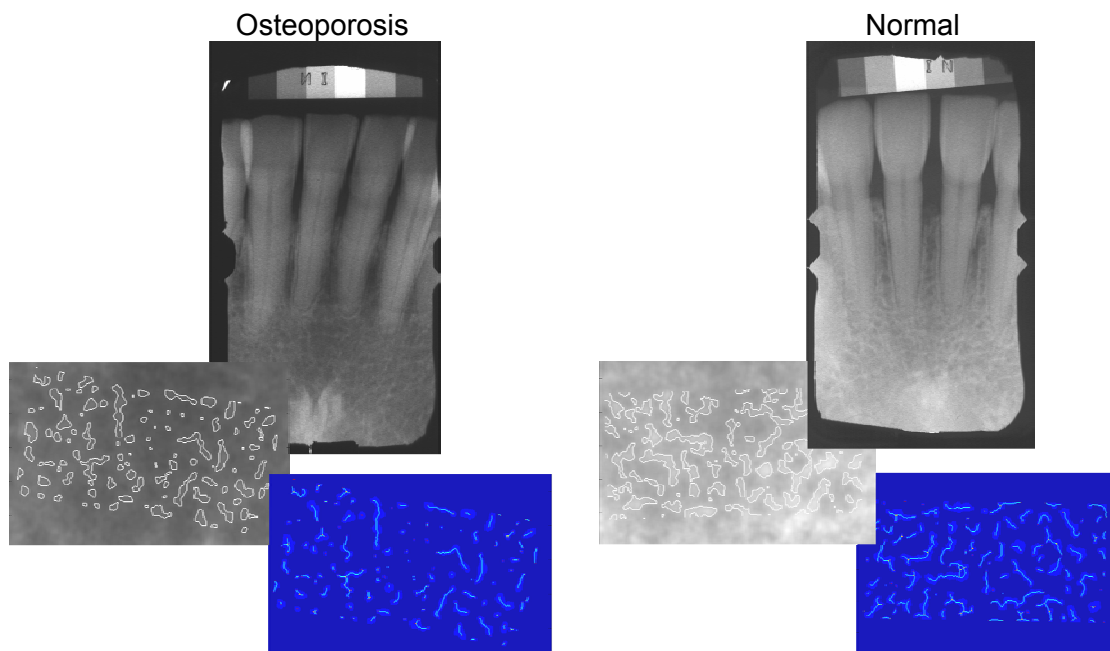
Examples of dental x-rays of osteoporotic (left) and normal (right) subjects. Both density and structural features differ between the two.
